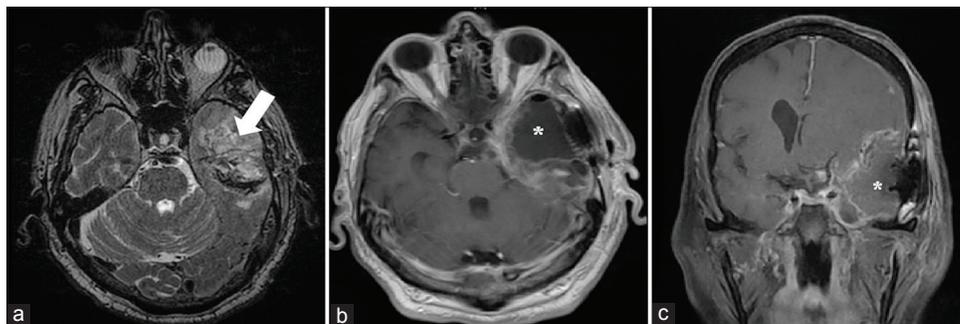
Pre- and post-operative magnetic resonance imaging of the second patient's left temporal glioblastoma and its resection cavity. (a) T2-weighted axial image demonstrates the patient's tumor (white arrow). (b) Axial and (c) coronal MR images demonstrate the patient's post-operative resection cavity consistent with a left anterior temporal lobectomy. ((*) indicates the post-operative resection cavity in all panels).
